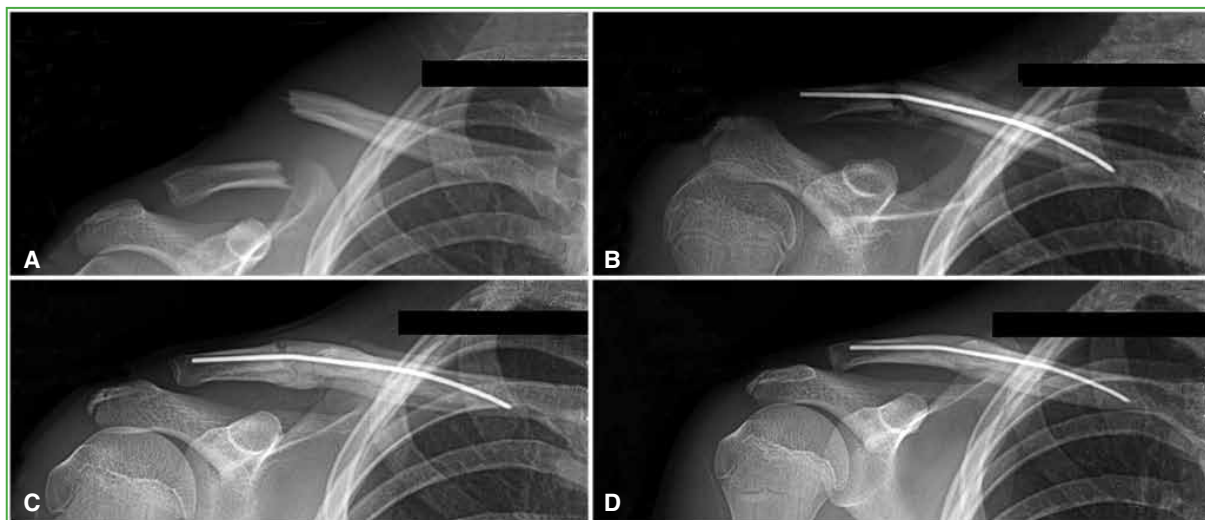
AP radiographs of the right clavicle. A. Simple midshaft fracture in a 13-year-old boy. B. Two weeks post-op via medial incision. Periosteal reaction not attributable to fracture callus. C. Nine weeks: partial ossification of the periosteal reaction with increased cortical thickness. D. One year: advanced remodeling without full return to original diameter.
